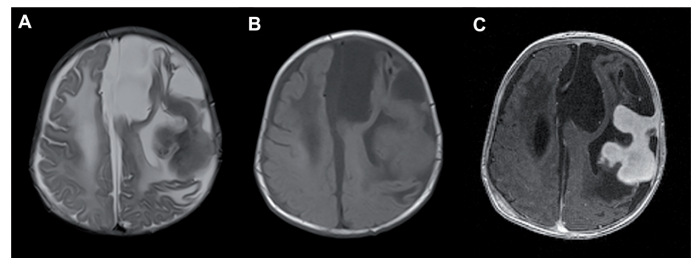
Two-month-old male with left frontal lobe desmoplastic infantile ganglioglioma (Case 7). Pre-contrast transverse T2-weighted (A) and T1-weighted (B) and post-gadobutrol T1-weighted MR images show a lobulated left cerebral hemisphere mass. Gadobutrol-enhanced image (C) shows homogeneous enhancement of the tumor with notable enhancing extension of the tumor to the dura laterally, a distinguishing feature of this tumor.
